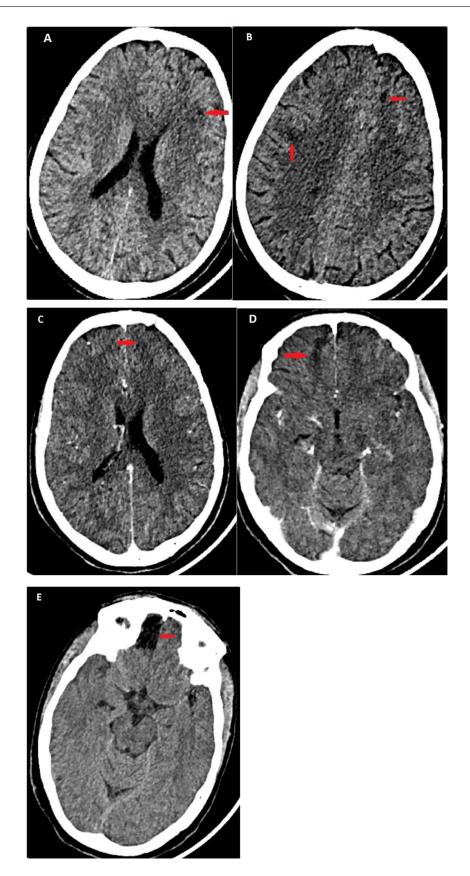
Axial CT with and without contrast: shows some subcortical hypodensity in the frontal region bilaterally (A, B) and 2 bilateral frontal cortico-subcortical low attenuation areas (C, D), poorly limited for most of them, unchanged after contrast injection, possibly related to foci of encephalitis. It also shows a right basifrontal porencephalic cavity, similar in density to the CSF, with a sequellar ischemic appearance (E).
